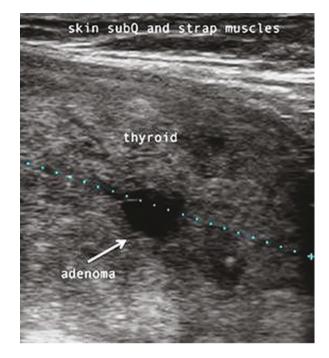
Parathyroid adenoma identified on intra-operative ultrasound: (a) During ultrasound in the office setting, no parathyroid adenomas were identified in the neck (in a patient with negative nuclear scan). (b) In the operating room with the patient under anesthesia and the neck hyper-extended, gentle pressure with the transducer identified a parathyroid adenoma posterior to the right thyroid lobe
